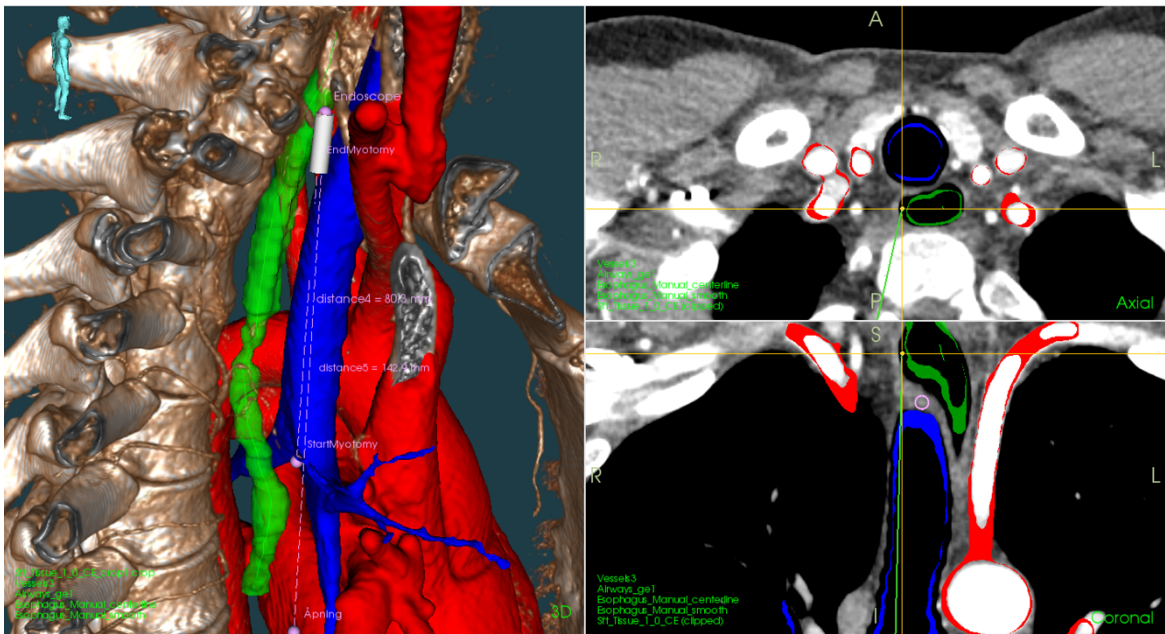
3D model reconstructed from CT presented in the navigation system, CustusX. Left: The navigation system showing the sensor in the endoscope (white), esophagus (green), vessels and heart (red), airways (blue) and axial skeleton in 3D (white-brown). Right: Axial and coronal CT slices are visualized with segmented structures overlay. The center of the yellow cross indicates the real-time sensor position.
